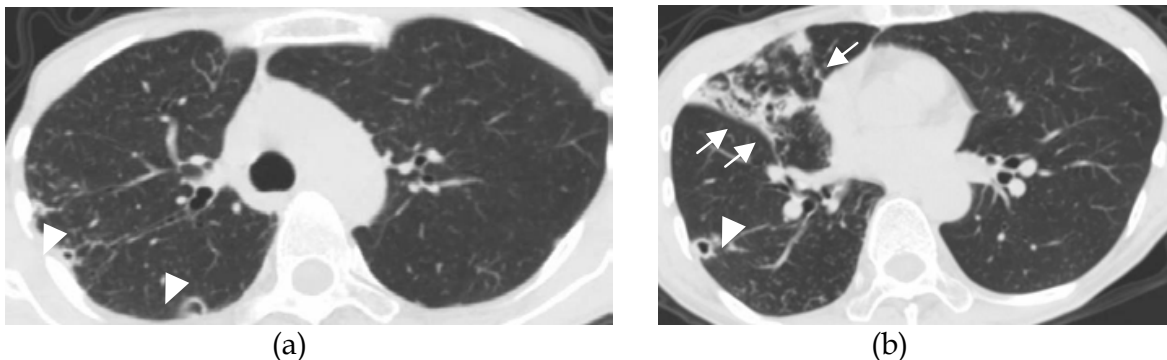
HRCT images of the lungs of a 63-year-old woman with MAC-PD. *M. avium* was detected in several sputum cultures. (a) Cavities with thick walls and no air-fluid level were seen in the right upper lobe (arrowheads) (b) Bronchiectasis with infiltration in the right middle lobe (arrows) and a cavity in the right lower lobe (arrowhead) were detected.
